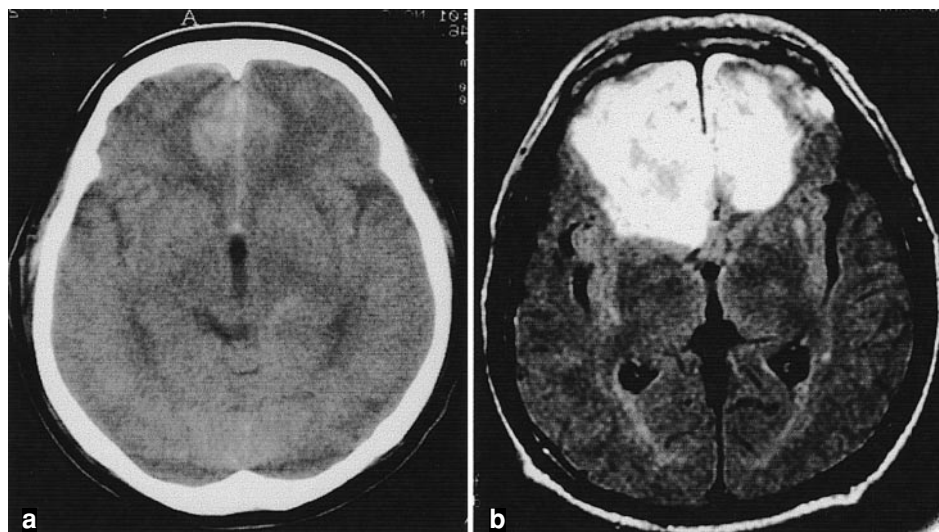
Computed tomography (CT) scan revealed bifrontal contusion and interhemispheric subarachnoid hemorrhage (a). Magnetic resonance (MR) imaging was performed 3 days later, and showed the same finding as those of CT scan (b)
